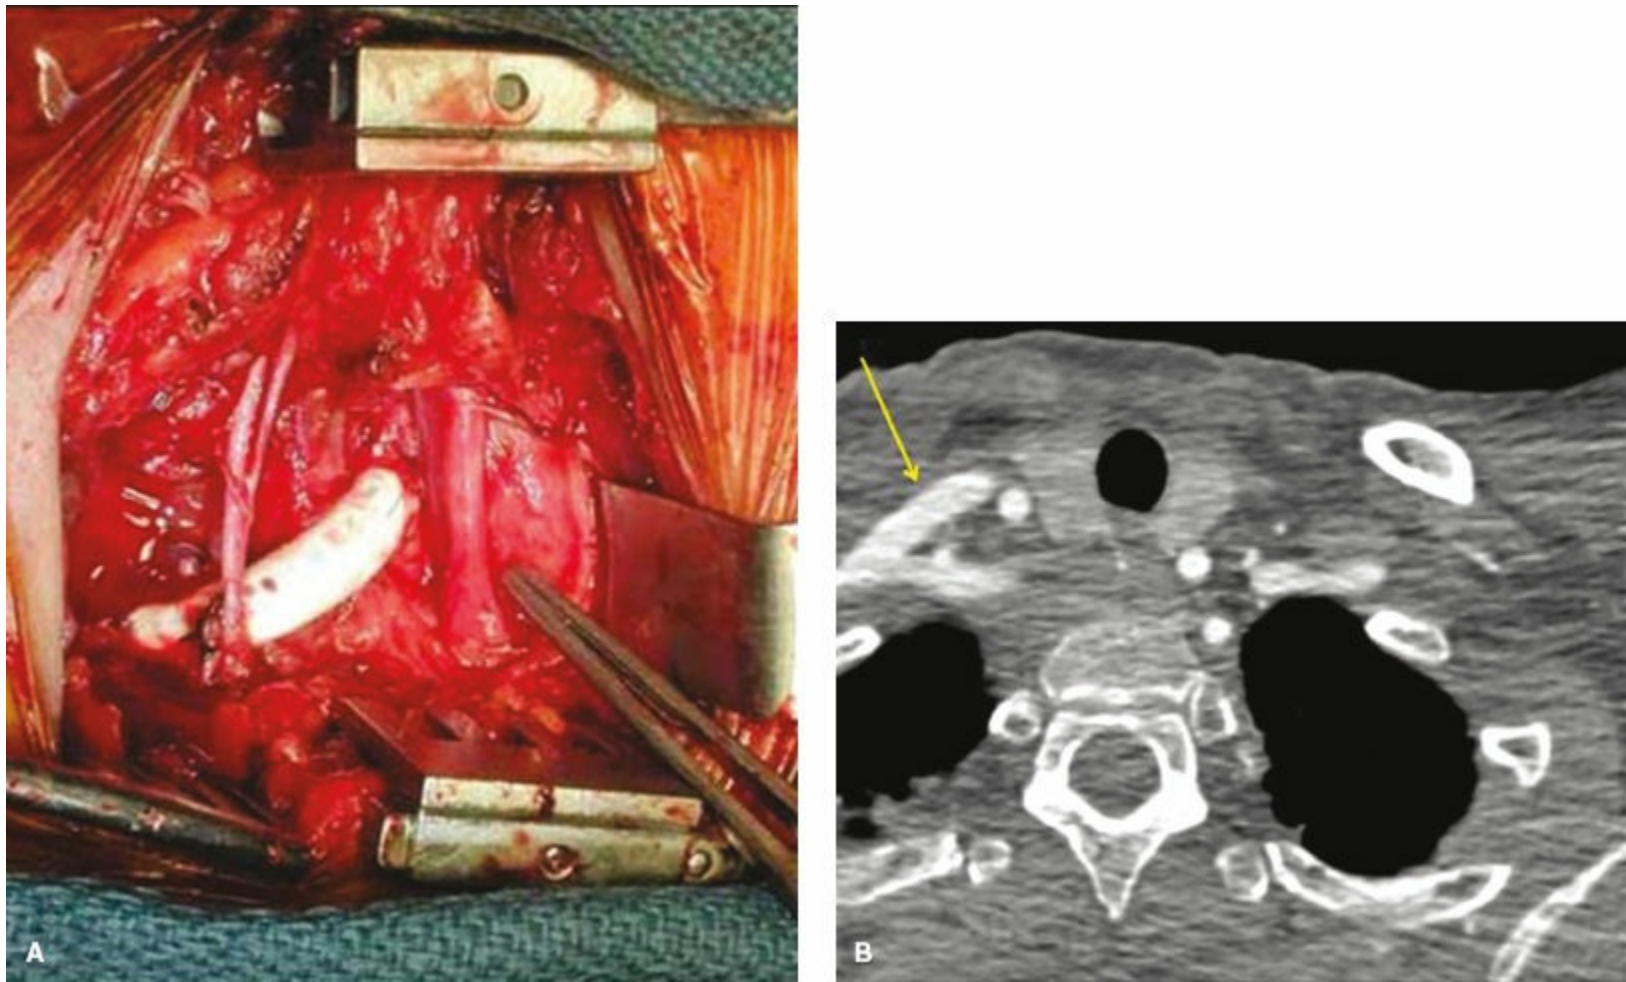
A: Right carotid to subclavian bypass performed via a supraclavicular incision using a prosthetic 10-mm conduit. B: CT scan showing patency of the bypass.
